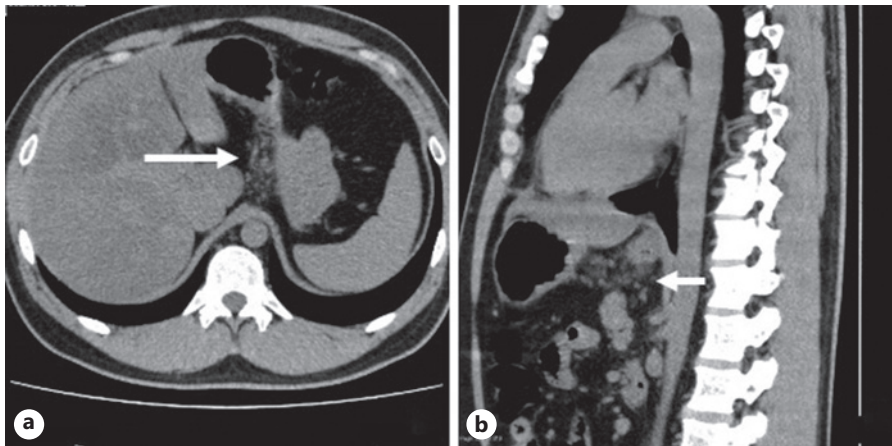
Abdominal CT image of *A. simplex*. Axial (a) and sagittal (b) views of computed tomography images show fat stranding around the cardiac and fundic muscle lesions of the stomach.
